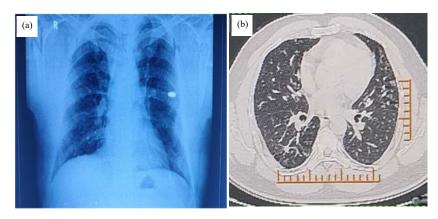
(a) Chest X-ray (PA) with nodular calcifications and right hilar lymphadenopathy(in circle) and (b) HRCT thorax showing fibronodular opacities with calcified lymph nodes (arrow marks) in both lung fields s/o of healed chronic granulomatous disease
